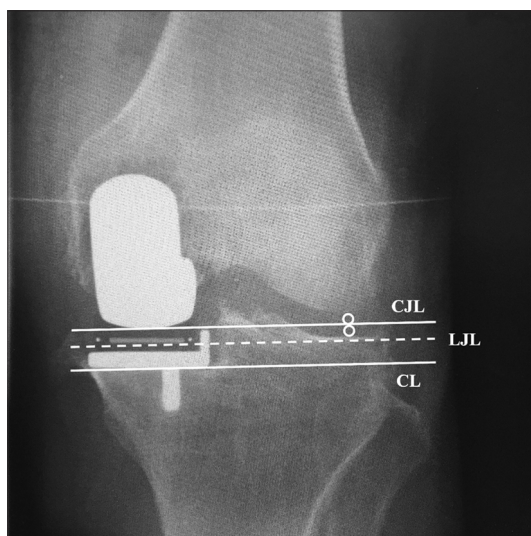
Postoperative radiographic evaluation. The bone-cutting line (CL) is virtually parallel with the coronal knee joint line (CJL). Note that the lateral joint line (LJL) is also parallel with the CL and CJL.
